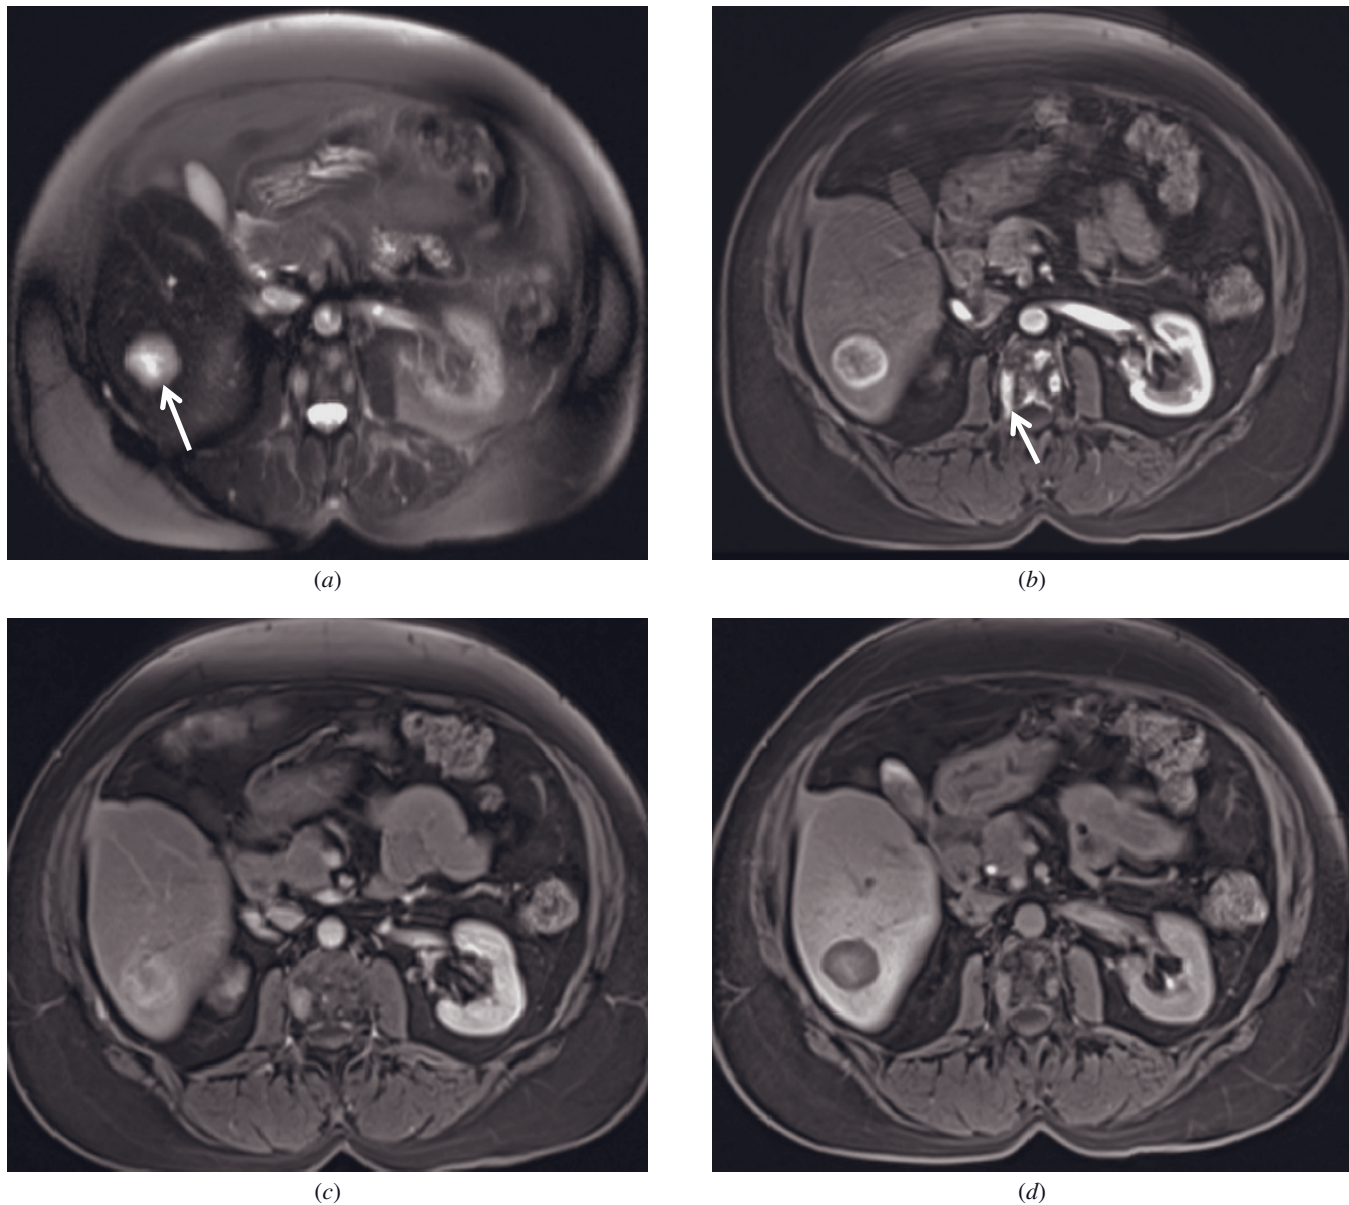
Multiple myeloma metastases in the liver and vertebra. T2-weighted single-shot echo-train spin-echo (*a*), T1-weighted fat-suppressed 3D-GE hepatic arterial dominant phase (*b*), interstitial phase (*c*), and 20-min hepatocyte phase (*d*) images demonstrate liver metastasis (arrow, *a*) and multiple bone metastases (arrow, *b*) from multiple myeloma after the administration of gadoxetic acid. The liver metastases show prominent peripheral enhancement on the hepatic arterial dominant and interstitial phases and minimal enhancement on the hepatocyte phase. The bone metastases show prominent enhancement.
